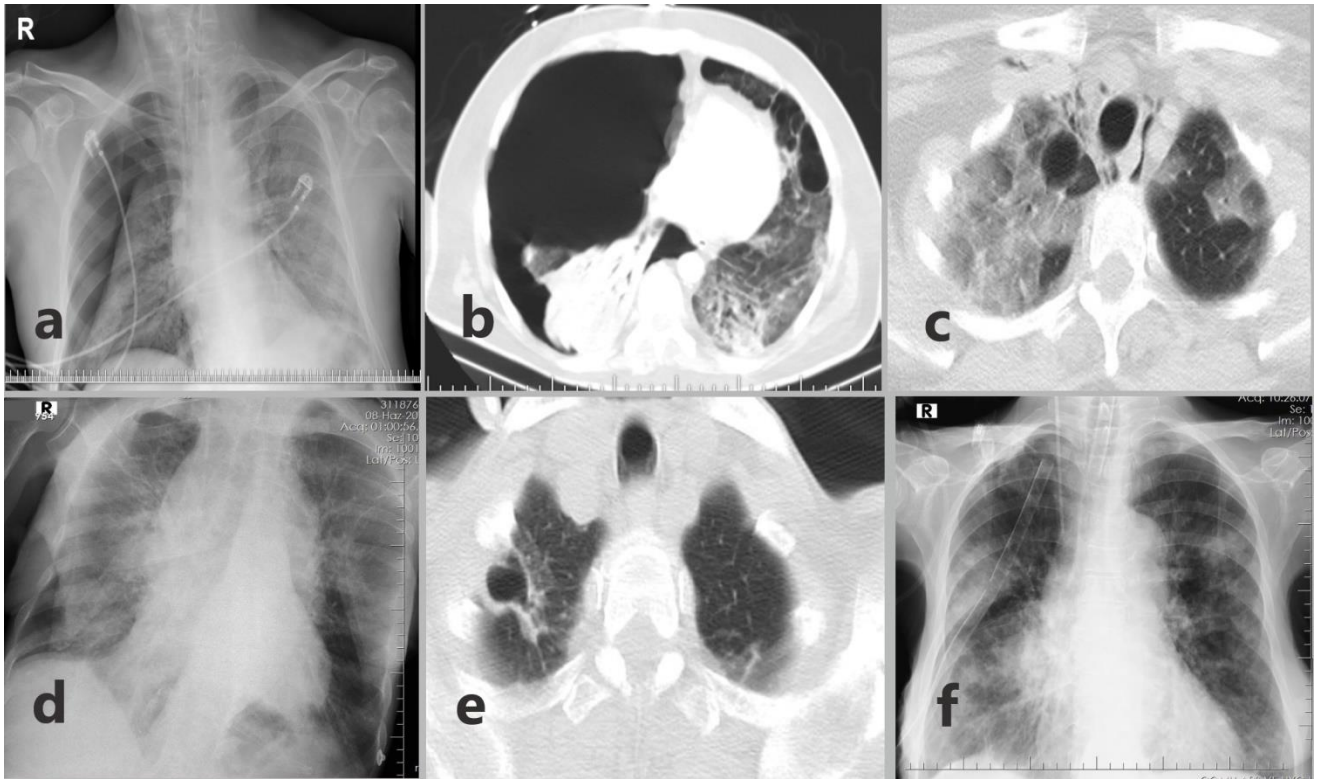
Figure 2a: chest radiograph (anteroposterior projection)-Large Right-sided pneumothorax Figure 2b: CT Chest- Right pneumothorax with atelectasis of right lower lobe and Left-sided pneumatocele/bullae seen with associated left lower lobe ground glass opacities. Figure 2c: Chest CT- showing pneumomediastinum and Right-sided pneumatocele/bullae seen with associated bilateral superior lobe ground glass opacities. Figure 2d: chest radiograph (anteroposterior projection): a female is her fifty-five presenting with a right pneumothorax. Figure 2e: CT Chest-Right-sided pneumatocele/bullae seen (before pneumothorax). Figure 2f: chest radiograph (anteroposterior projection) after pneumothorax developed and chest tubes were placed.
